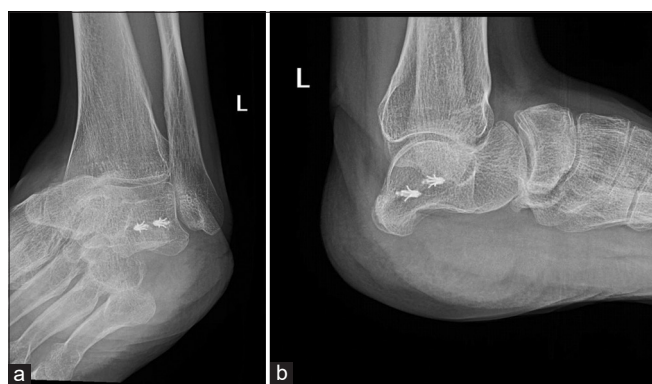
Radiographs at follow-up after 8 years (a) AP oblique view and (b) lateral view.
